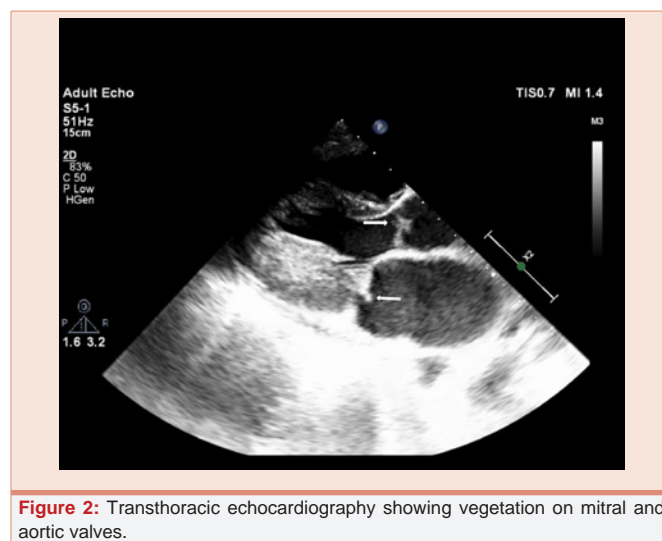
Transthoracic echocardiography showing vegetation on mitral and aortic valves.
